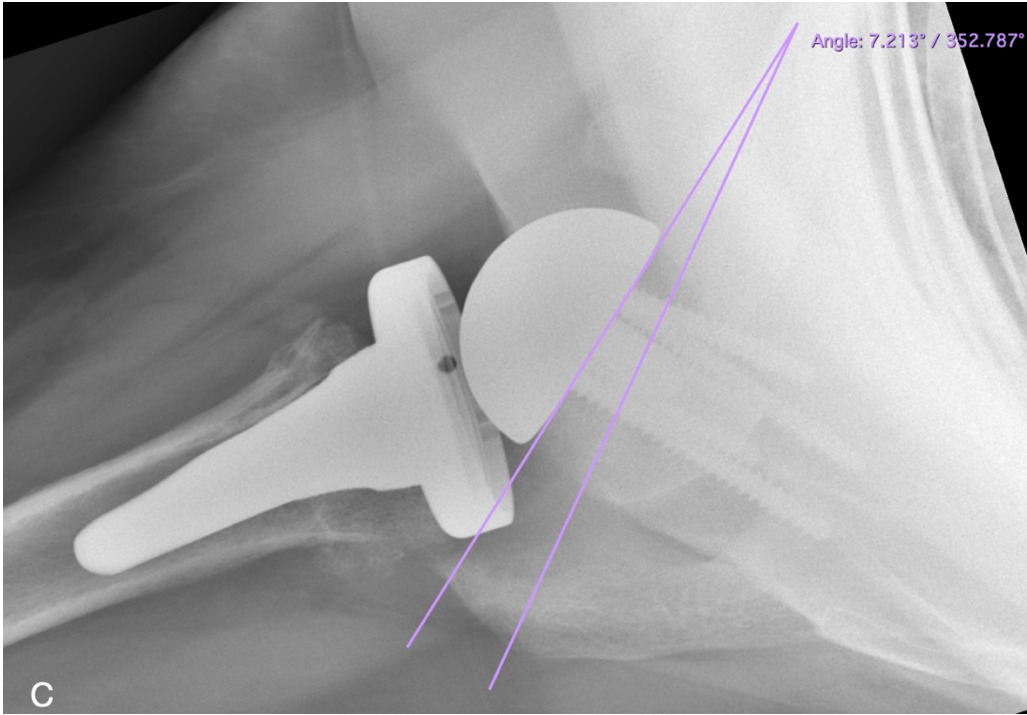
Cuff tear arthropathy with severe eccentric glenoid wear (E3 glenoid), A) orientation (28°) and direction (posterior-superior) of the glenoid wear, and the amount of posterior-superior humeral head subluxation (75%). B) 2D CT scan with the calculated values of glenoid retroversion and inclination, C) Postoperative axillary view radiograph after BIO-RSA with improvement of glenoid retroversion and good bone graft healing, D) Postoperative true AP radiograph of the BIO-RSA described in the figure 3C with the value of the β angle explaining the appropriate correction of superior glenoid inclination.
